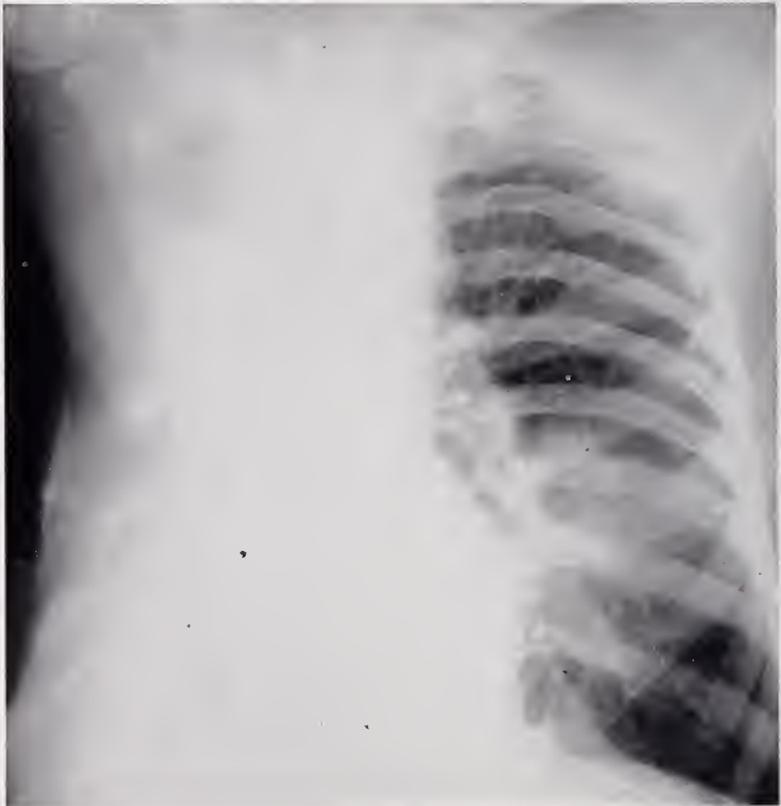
(X-ray). R. DeL. Oct. 2, 1951. Reactivation of tuberculosis in remaining lung after right pneumonectomy.
